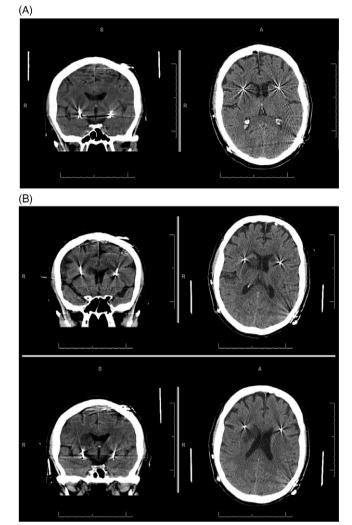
(A) Coronal and axial view of CT on POD1 showing a small IVH in the occipital horn of the right lateral ventricle. (B) Coronal and axial views of CT on POD2 showing new infarcts in the right internal capsule, right caudate nucleus, and left caudate nucleus.
